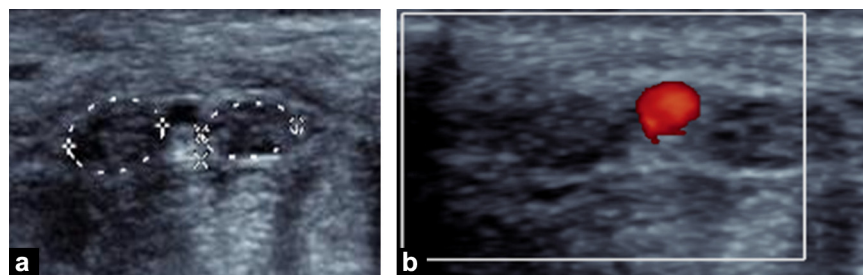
Bifid median nerve in a patient with carpal tunnel syndrome confirmed on electromyogram. a: on B mode ultrasound, the sum of the cross-sectional areas of the two components (dots) is measured (in this patient the surface is 12 mm²); b: Doppler ultrasound in power mode confirms patency of median artery.
